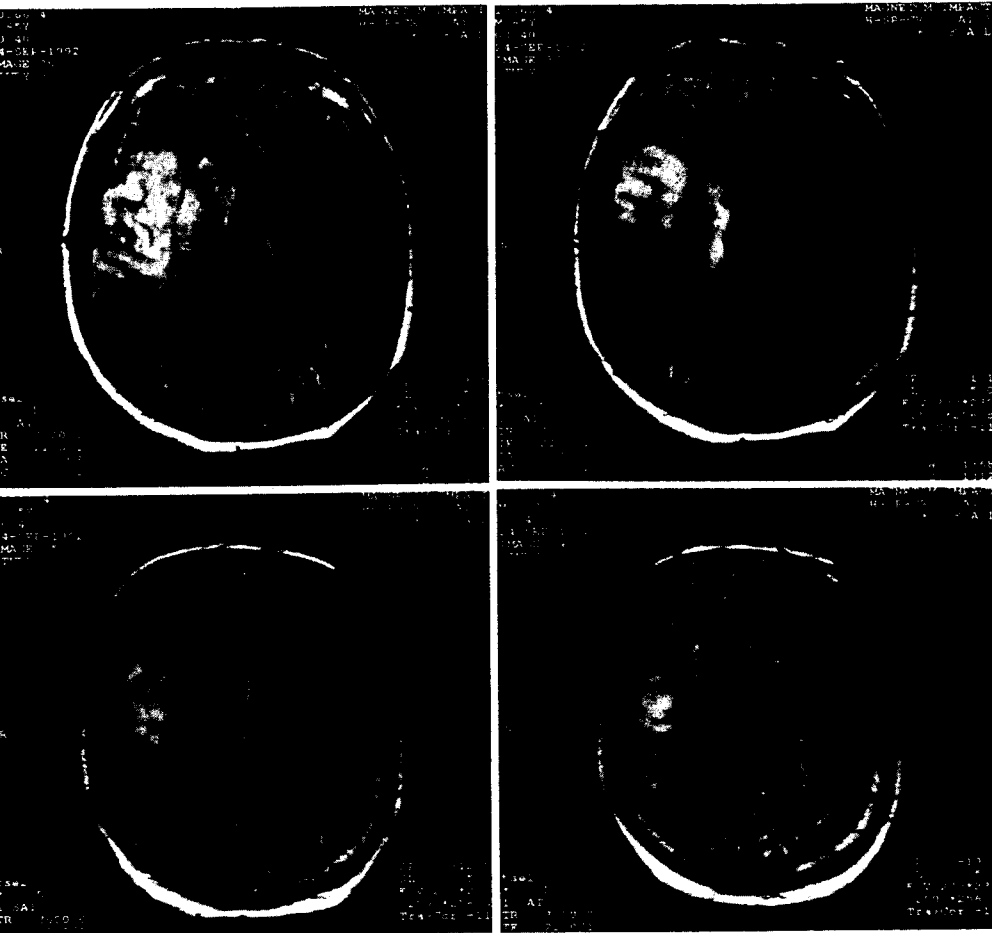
MRI of patient F.C. showing an infarction involving the right middle cerebral artery territory.
